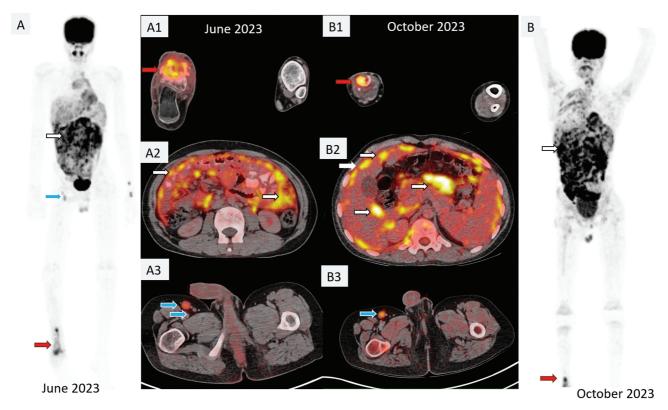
(A) Baseline whole-body maximum intensity projection image shows a lesion involving the distal right tibia (red arrow), diffuse abdominal uptake (white arrow), and right inguinal lymph nodes (blue arrow). Corresponding fused positron emission tomography/computed tomography (PET/CT) images show A1: fluorodeoxyglucose (FDG)-avid (standardized uptake value maximum [SUV max] 3.0) large lytic lesion involving distal right tibial metaphysis with soft tissue component involvement. It is associated with extraosseous component involvement (red arrow). A2: FDG-avid (SUV max 4.5) multiple variable-sized omental and peritoneal deposits (white arrow). A3: FDG-avid right inguinofemoral lymph node (blue arrow). Follow-up PET/CT MIP images (B) and B1 show residual lesions in the lower one-third of the right tibia (red arrow). Fused PET/CT in the abdomen region (B2) shows extensive FDG-avid variable-sized omental and mesenteric deposits (white arrow). B3: FDG-avid right inguinofemoral lymph node (blue arrow).
